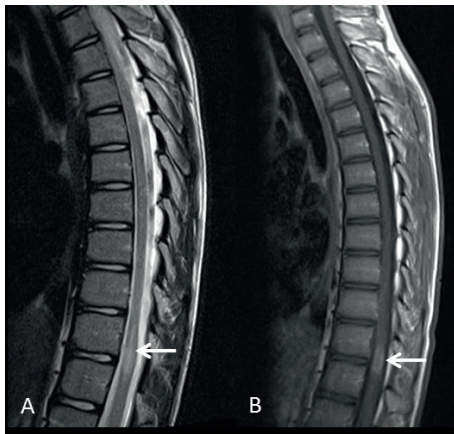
MRI of the neuraxis in a three-year-old boy with EV-D68 associated AFM. (republished with permission from [49])
